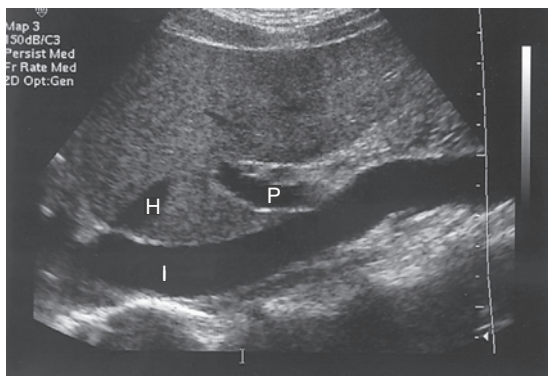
Main portal vein. A longitudinal sonogram shows main portal vein (P) as it enters hilum of the liver. The inferior vena cava (I) and hepatic vein (H) are also demonstrated.
